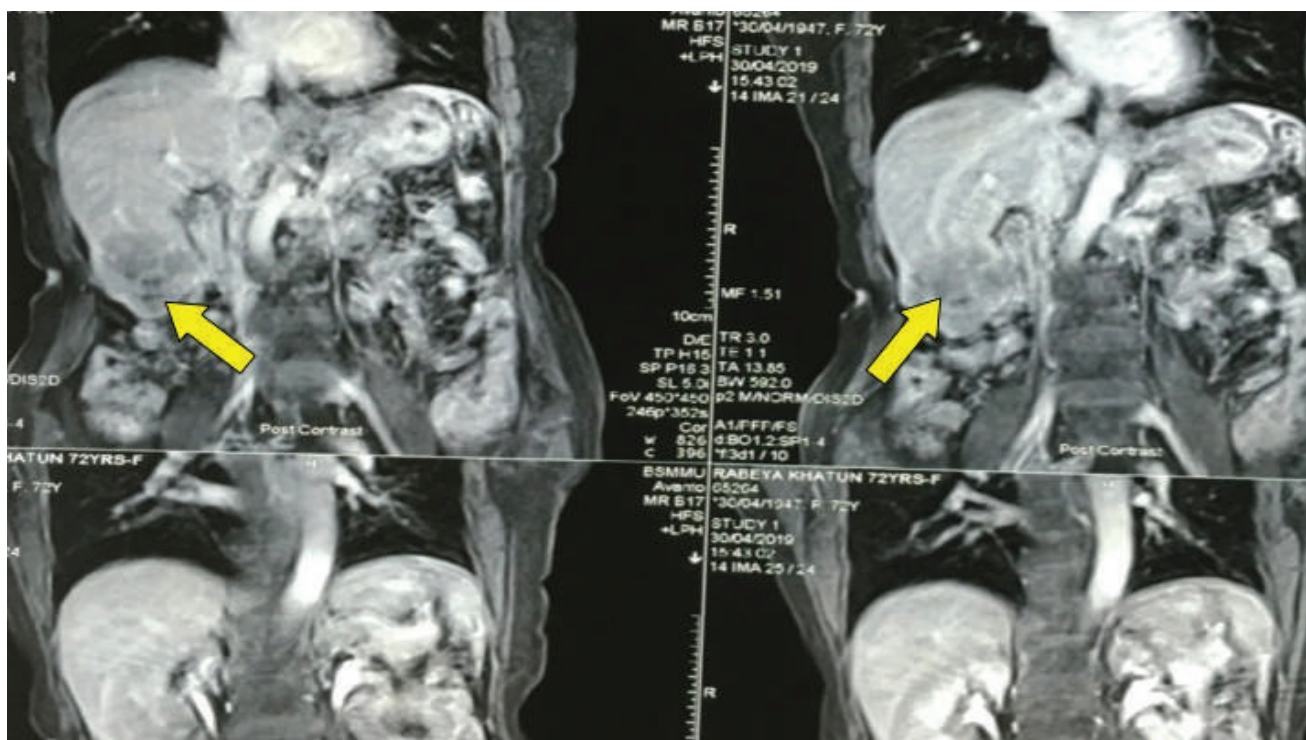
Computed tomography image of the mass lesion (yellow arrow) in segment V and VI of right lobe of liver.
